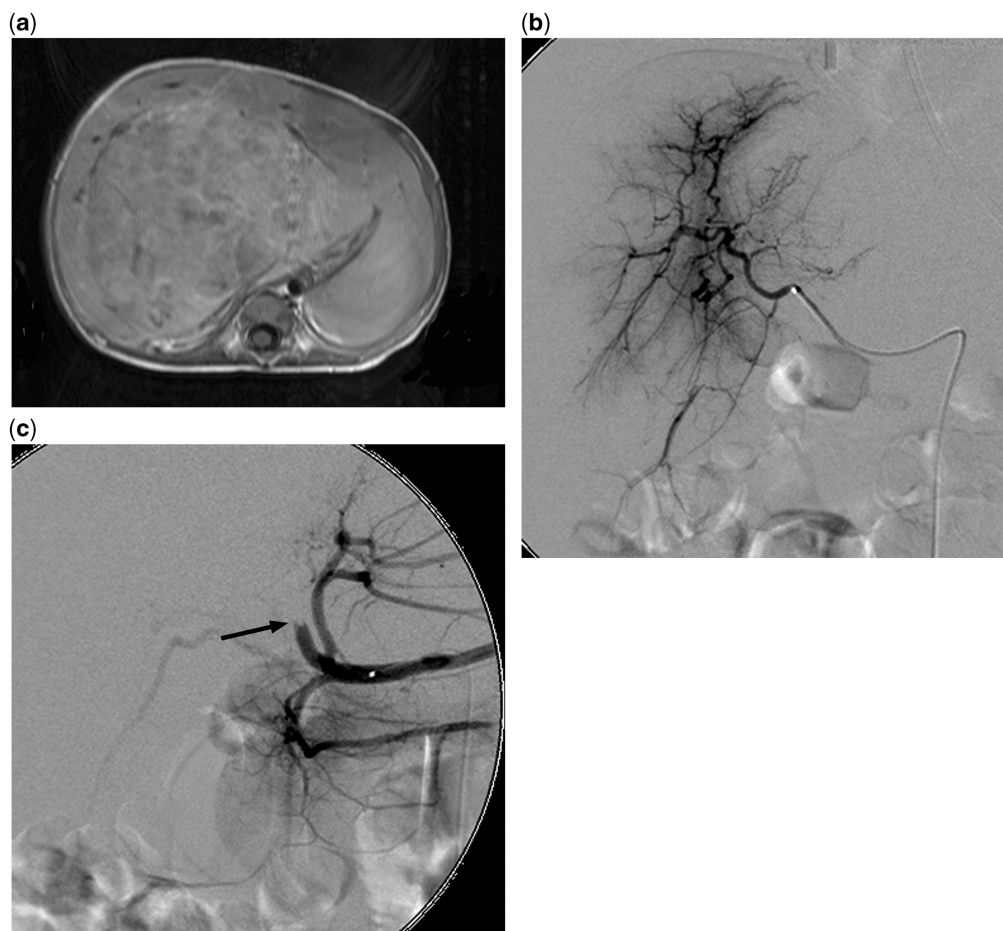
Hepatic artery chemoembolization (HACE) in a 15-month-old girl with hepatoblastoma. (a) Transverse contrast-enhanced T1-weighted MR image shows an unresectable liver tumour. (b) Right hepatic angiography using a microcatheter technique shows abnormal vascularity in the right lobe of the liver. (c) Following HACE with doxorubicin and cisplatin, the right hepatic artery (arrow) has been occluded with a temporary embolic agent.
